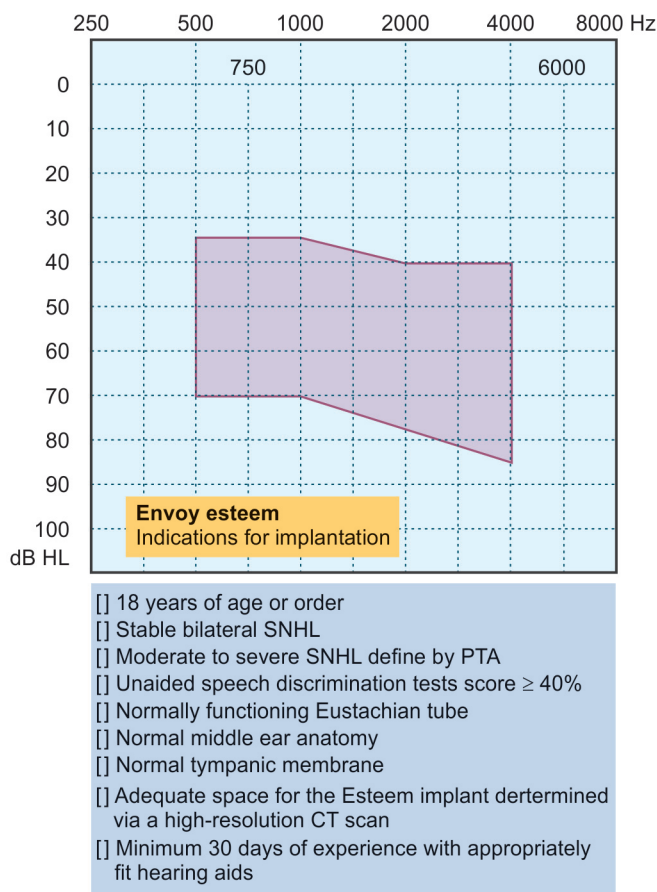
Envoy Esteem: manufacturer's clinical and audiometric guidelines for implantation. (CT, computed tomography; PTA, pure tone audiometry; SNHL, sensorineural hearing loss).
